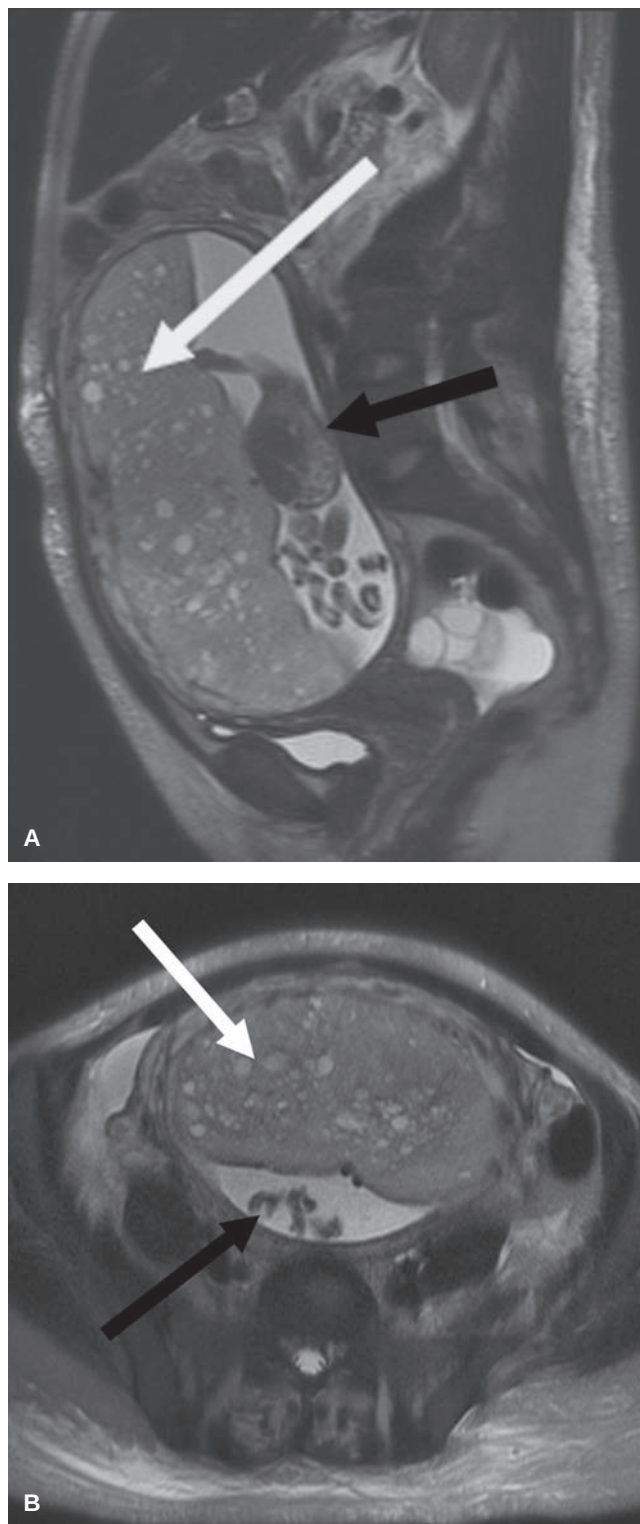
Partial mole. Sagittal (A) and axial (B) T2W FSE MR images demonstrate a heterogeneous mass within the uterus (white arrows). Fetal abdomen (black arrow in A) and umbilical cord (black arrow in B) can be seen adjacent to the mass.
